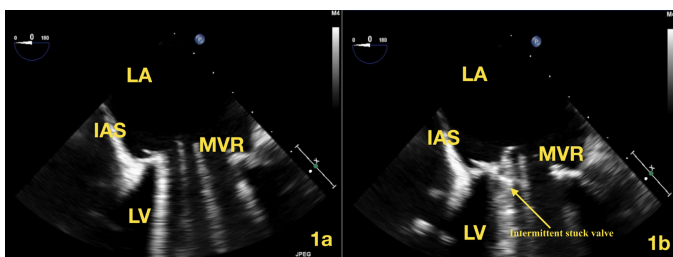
Transesophageal echocardiography images show intermittent entrapment due to thrombus, the arrow reveals stuck leaflet. LA, left atrium; LV, left ventricle; IAS, interatrial septum; MVR, mitral valve replacement.
